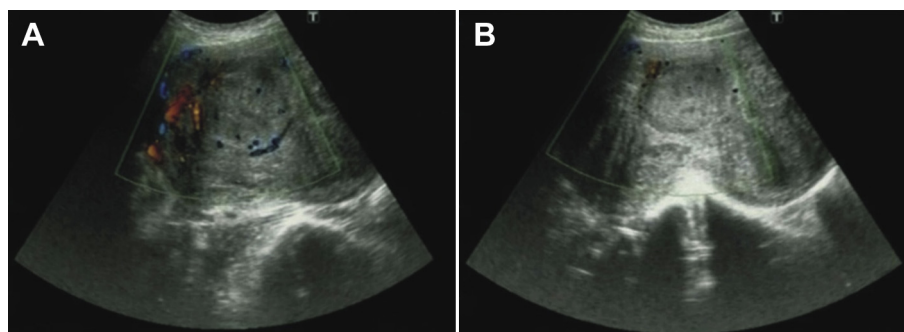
Comparison of the change of blood flow in the myoma on Color Doppler Misoprostol Response Study (A) before and (B) after misoprostol administration.
